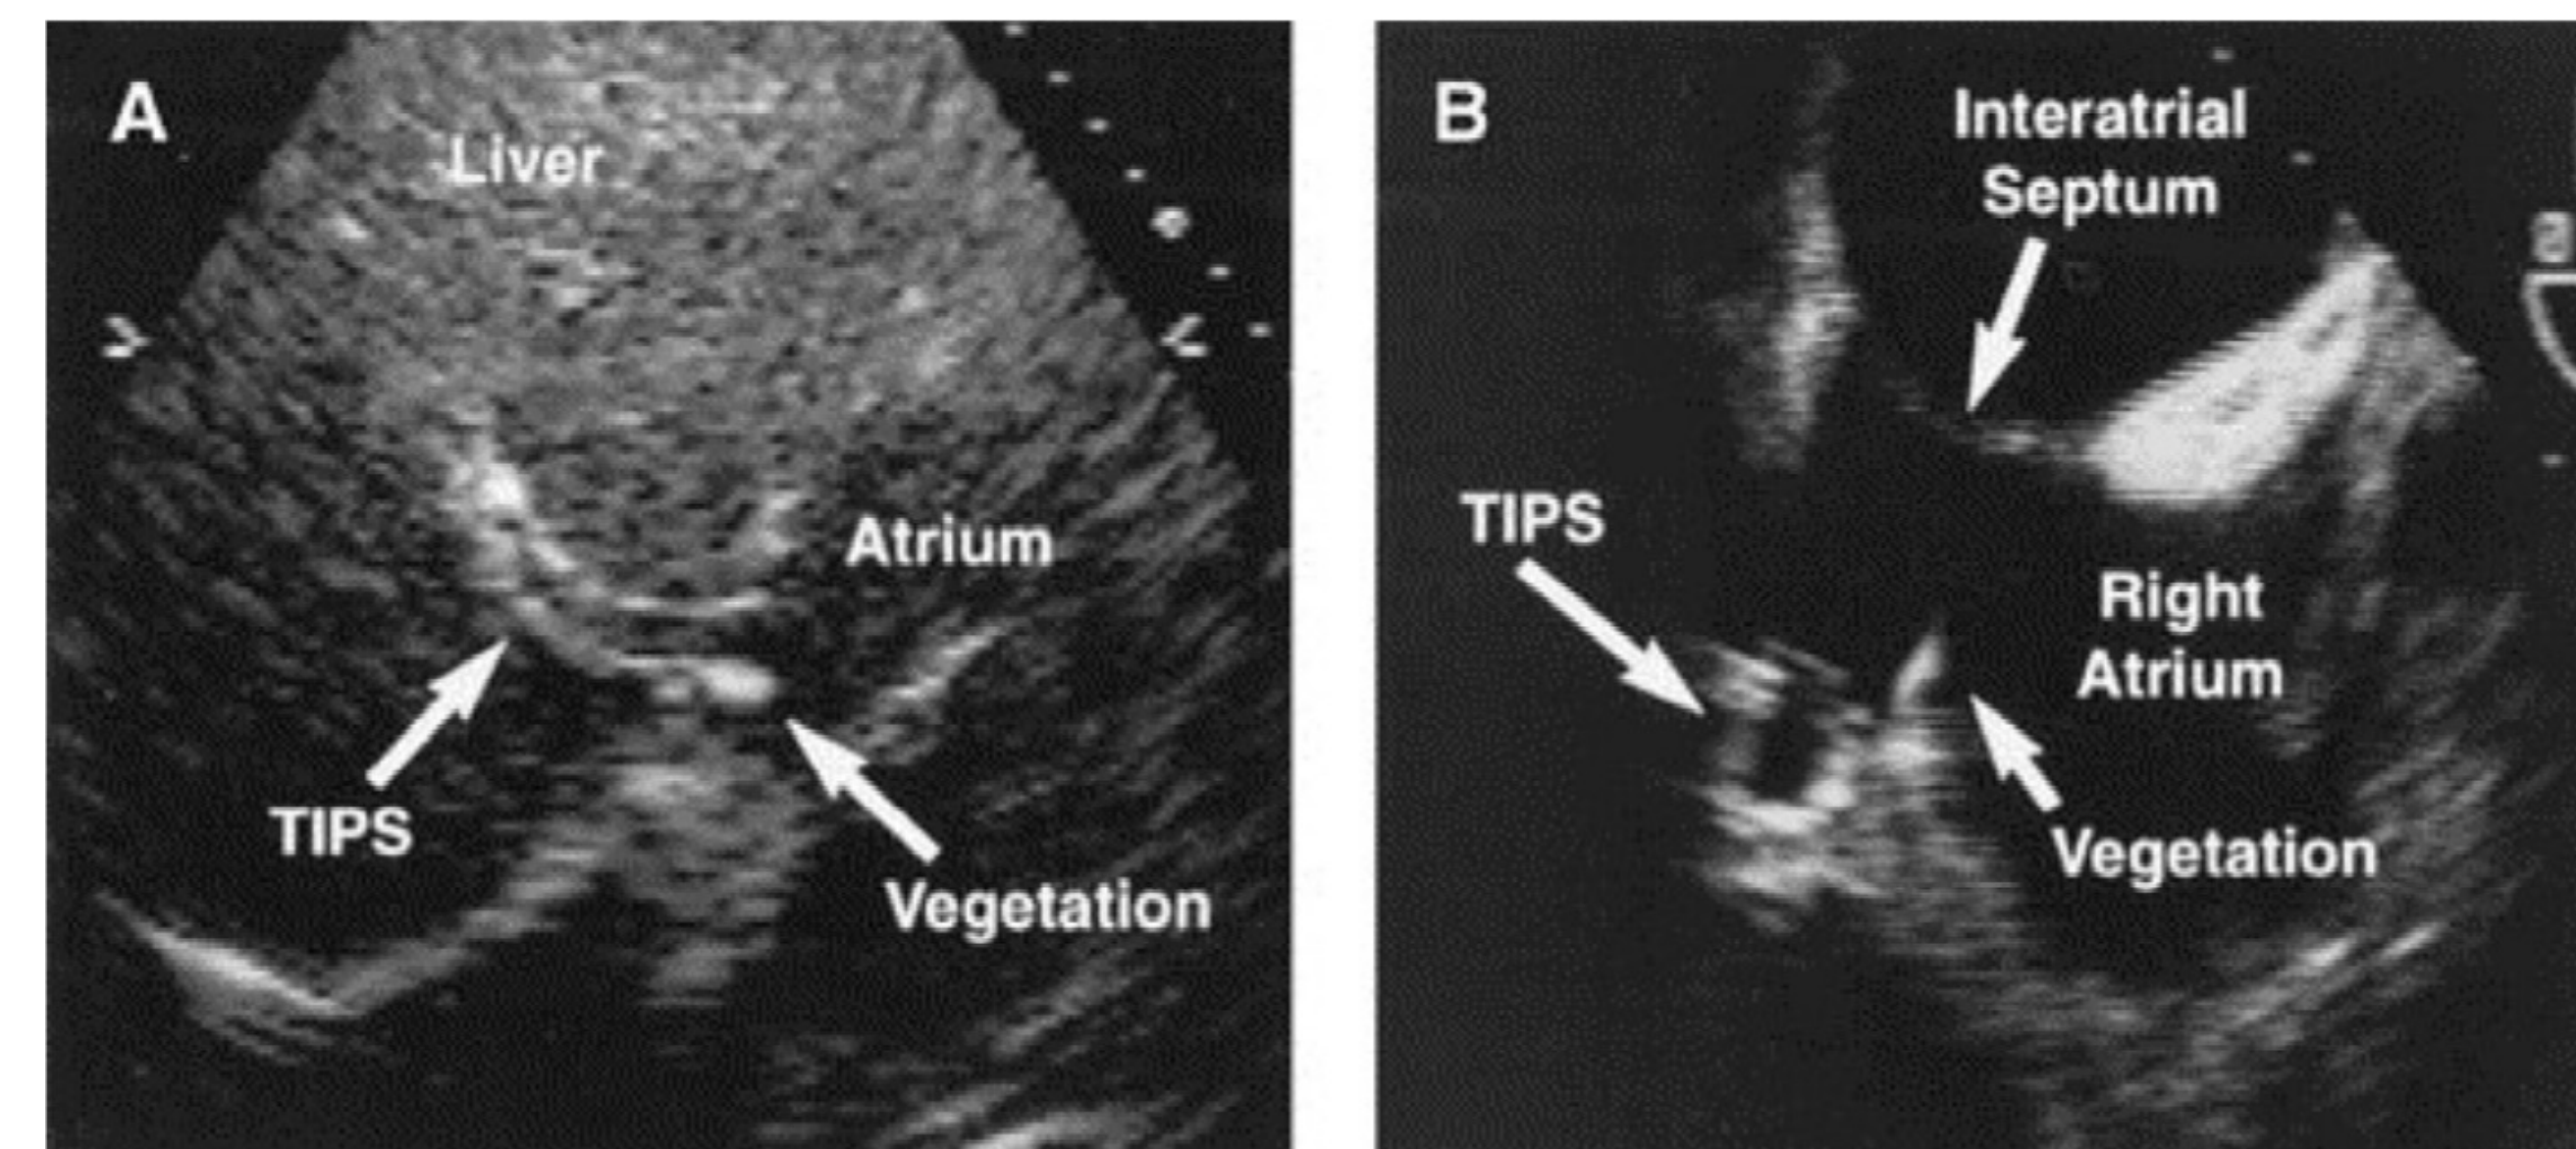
(A) Sonographic evidence of vegetation at the proximal end of a TIPS. (B) The stent extends back into the right atrium observed on transesophageal echocardiography at the atrial end of the stent.
